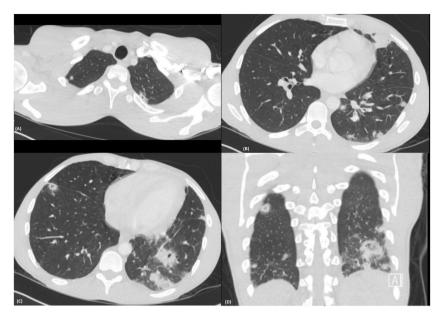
CT angiography of the chest showing multiple, fluffy, nodules of varying size and ill-defined margins throughout both lungs.
